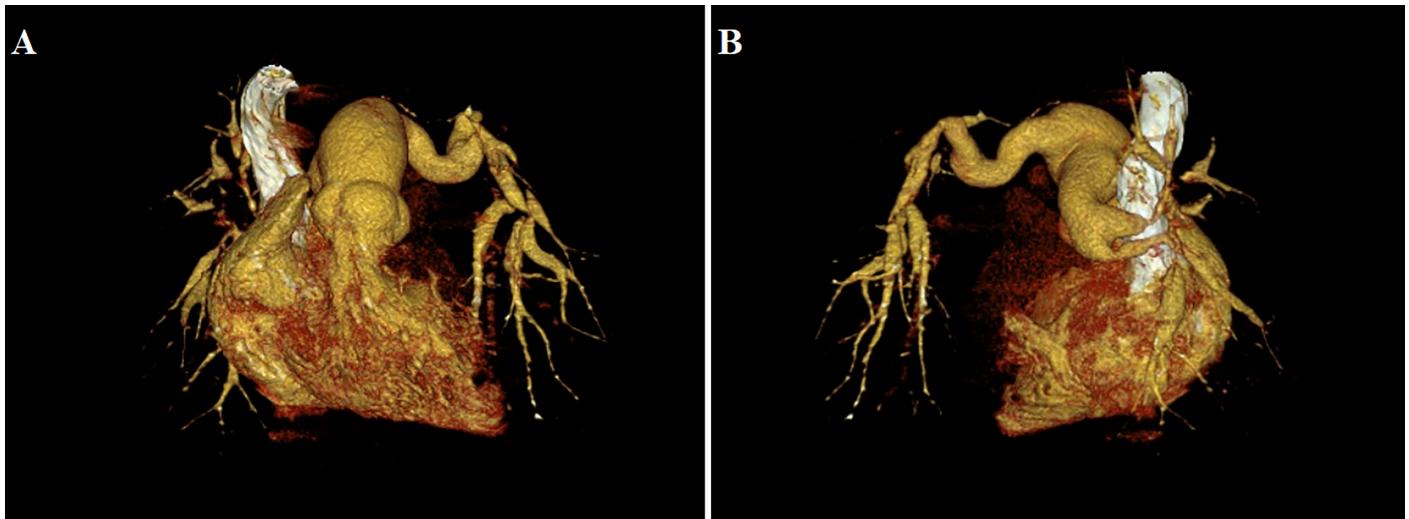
(A) Anterior view of pulmonary artery with computed tomography angiography with three-dimensional (3D) volume rendering technique. (B) Posterior view of pulmonary artery with computed tomography angiography with 3D volume rendering technique.
